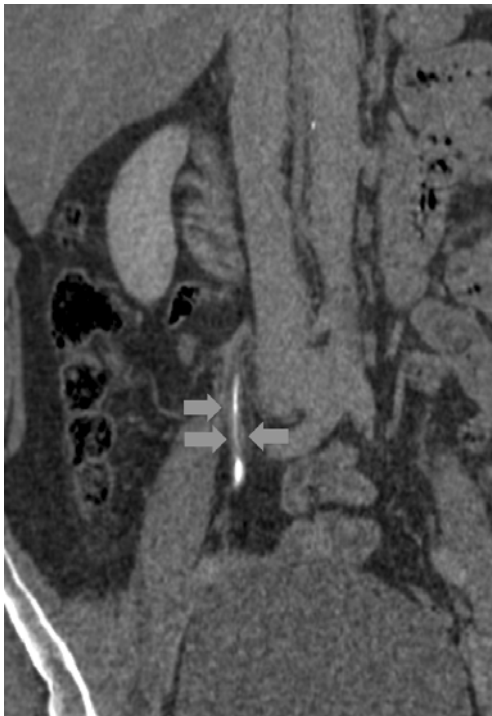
Excretory-phase CT urography. Coronal multiplanar projection showing circumferential wall thickening of the right ureter due to urothelial cancer.
